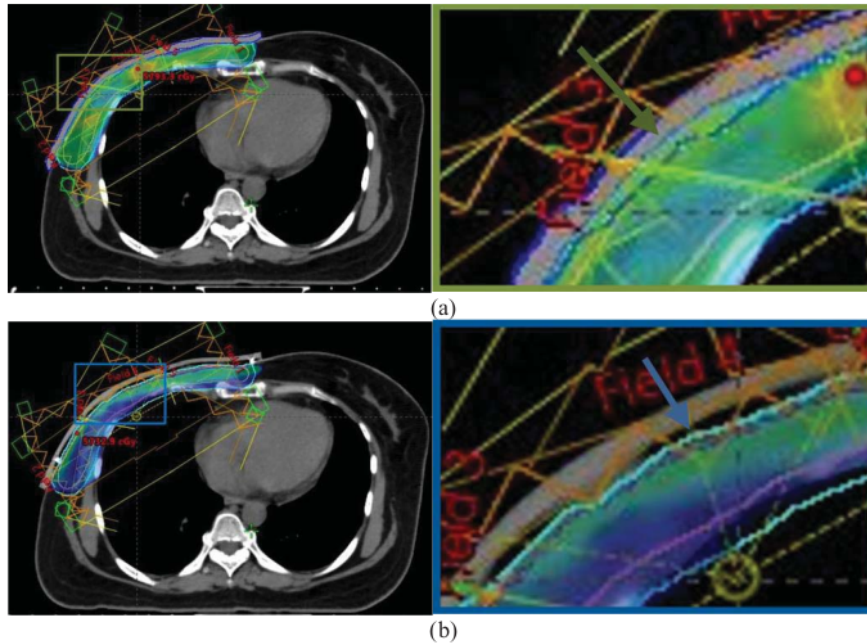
Pair of CT image slice for IMRT planning, notice, although not very visible, skin with underdose still present in IMRT with plasticine bolus (blue arrow).
